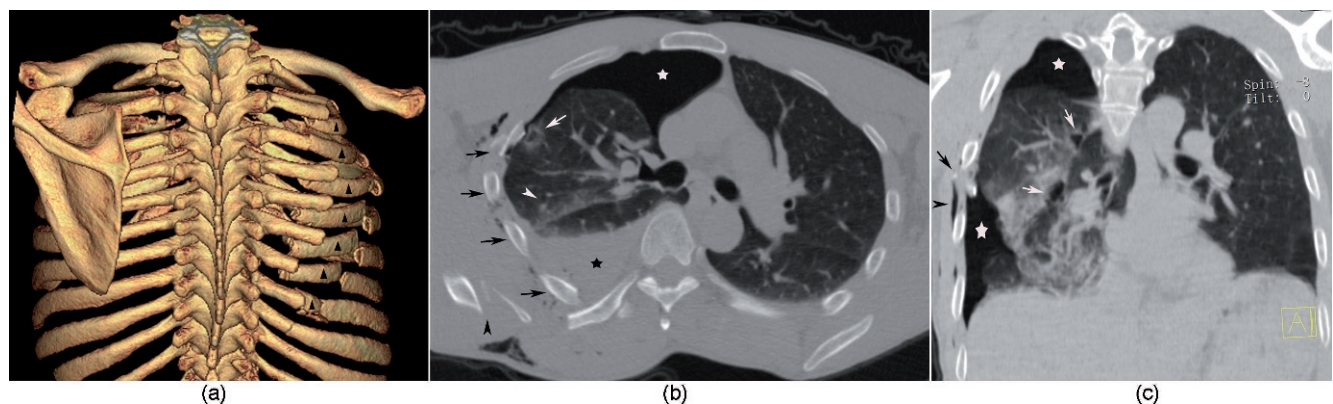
Flail chest in a 46-year-old man. (2A) The surface-shaded display shows thoracic cage asymmetry caused by right-side rib 2–8 fractures at multiple sites causing flail chest (▲), and fractures of right-side ninth rib of posterior location. (2B) The axial CT scan shows a right-side hemothorax (★), pneumothorax (☆), and pulmonary parenchymal injuries, including contusion (write arrowhead) and laceration (write arrow), thoracic cage asymmetry caused by right-side rib fractures (black arrows), and a right scapular fracture (black arrowhead). Right-side subcutaneous air collection is also depicted. (2C) The coronal multi-planar reconstruction shows a right-side pneumothorax (☆), a pulmonary parenchymal laceration (write arrows) and a contusion, right-side rib fractures (black arrow), and right-side subcutaneous air collection (black arrowhead).
